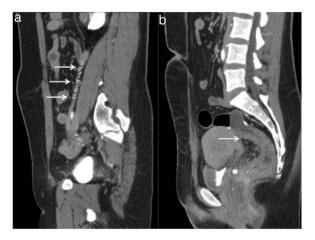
Sagittal view of a CT scan showing a) blood vessel tortuosity and b) thickening of the rectal wall below the ileorectal anastomosis and phleboliths in the cul-de-sac.
